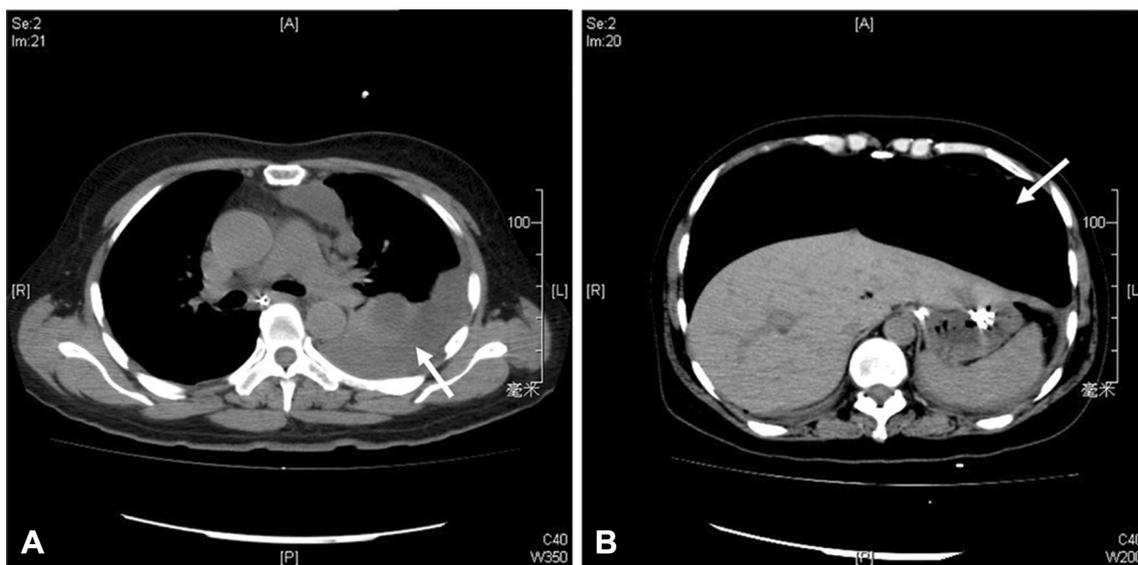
ER-related complications. A Major hydrothorax was detected at 3 days after the endoscopic procedure via CT. B CT of a patient with major pneumoperitoneum showed large pneumatosis in the peritoneal cavity
